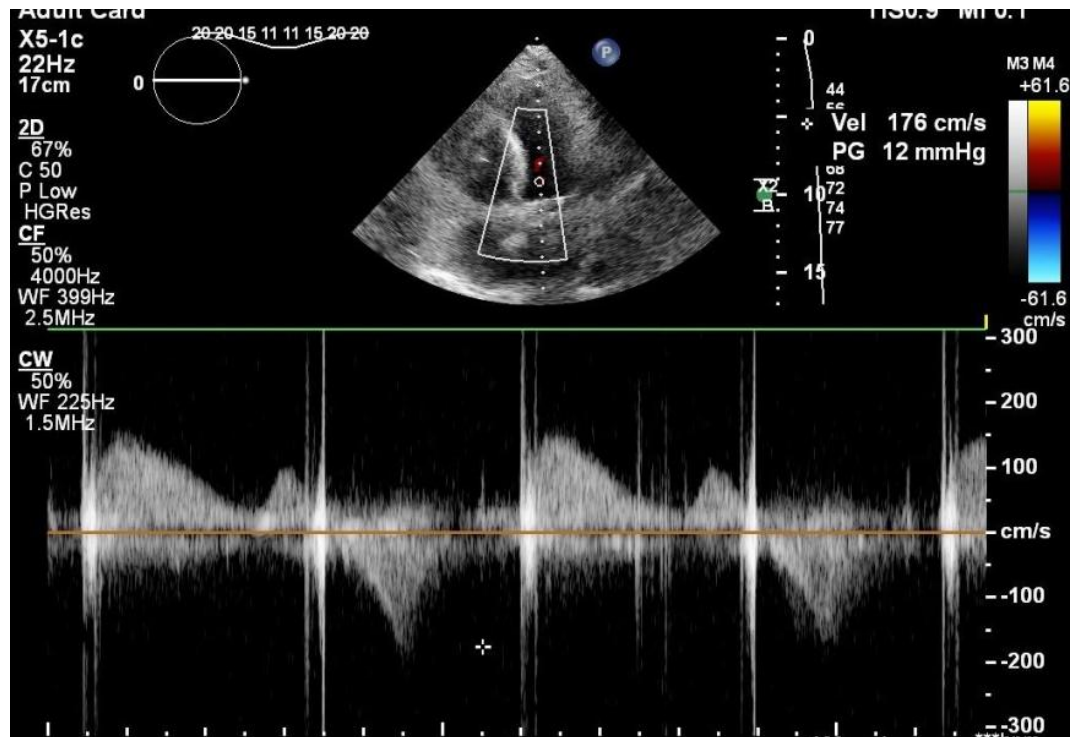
Transthoracic echocardiography 5 C view: postoperative peak flow velocity reduced to 1.7 m/s
